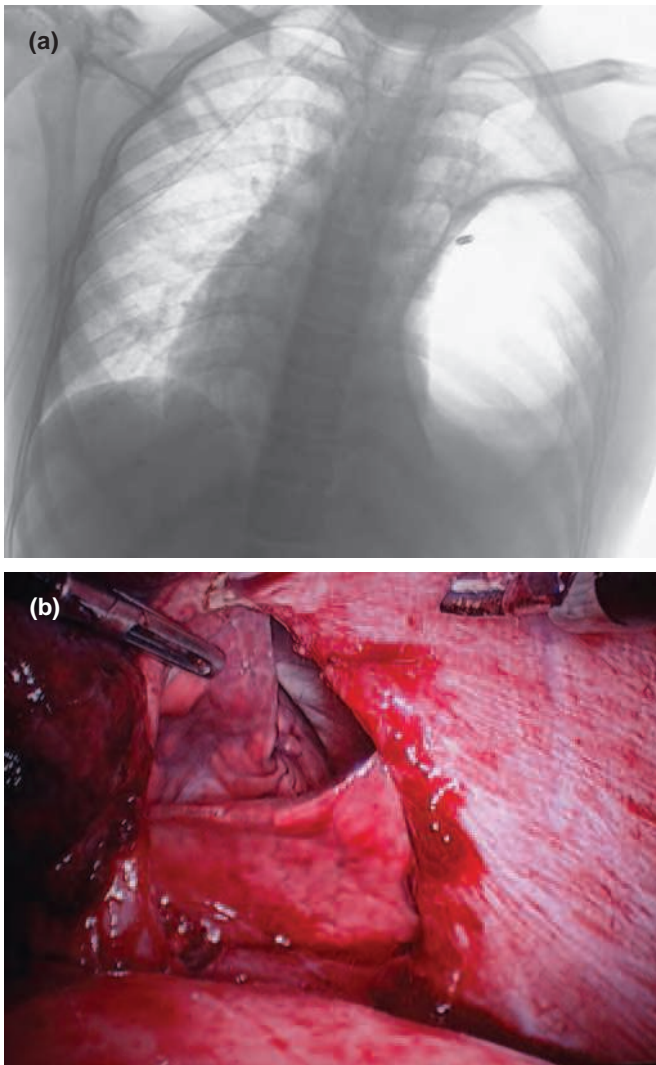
(a) Chest radiograph of a patient with traumatic diaphragmatic hernia, showing bowel contents in the thoracic cavity (b) Diaphragmatic rent as seen through laparoscope in the same patient
